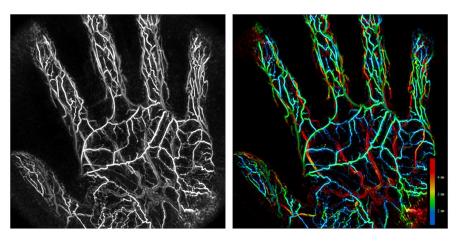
Kyoto University (Japan) researchers used PAI to create three-dimensional maps of blood vessels inside human palms. It contains a hemispherical ultrasound detector array and dual 755 nm and 795 nm lasers. The research team was only interested in measuring total blood concentration and thus chose to exclusively use the 795 nm signal. This is where the absorption coefficients of HHb and HbO $_2$ are equivalent. From: Matsumoto⁵⁹.
